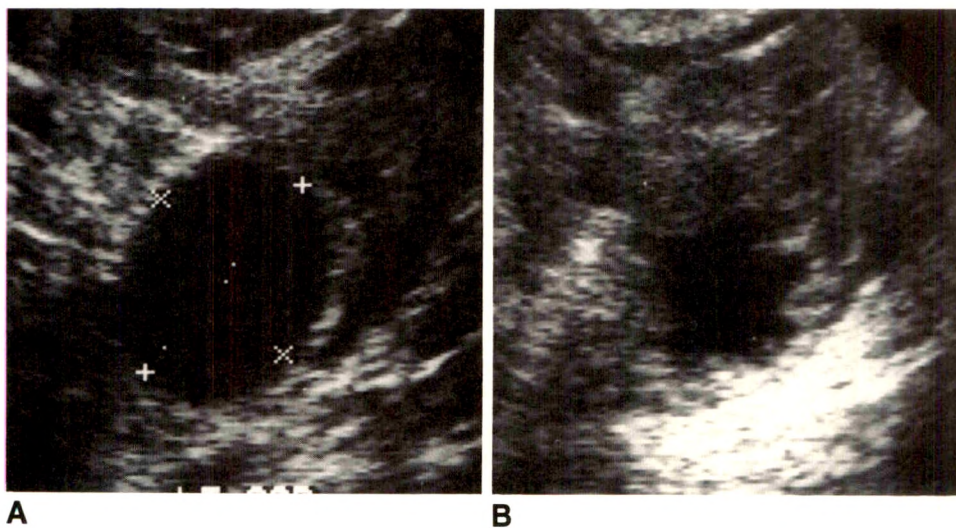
Serial sonograms show crenation of dominant follicle after ovulation.
